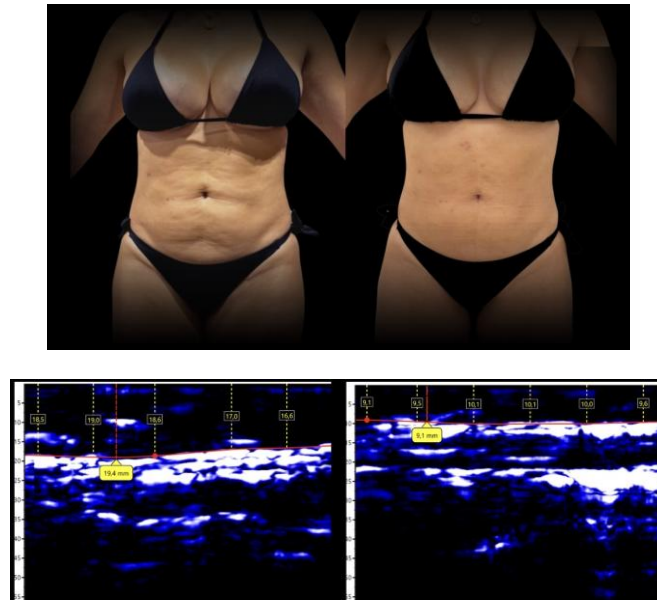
Patient 1: photographic and ultrasound documentation before and after the protocol (19.4 and 9.1 mm). Images from the author's clinical records, published with the patient's authorization.
